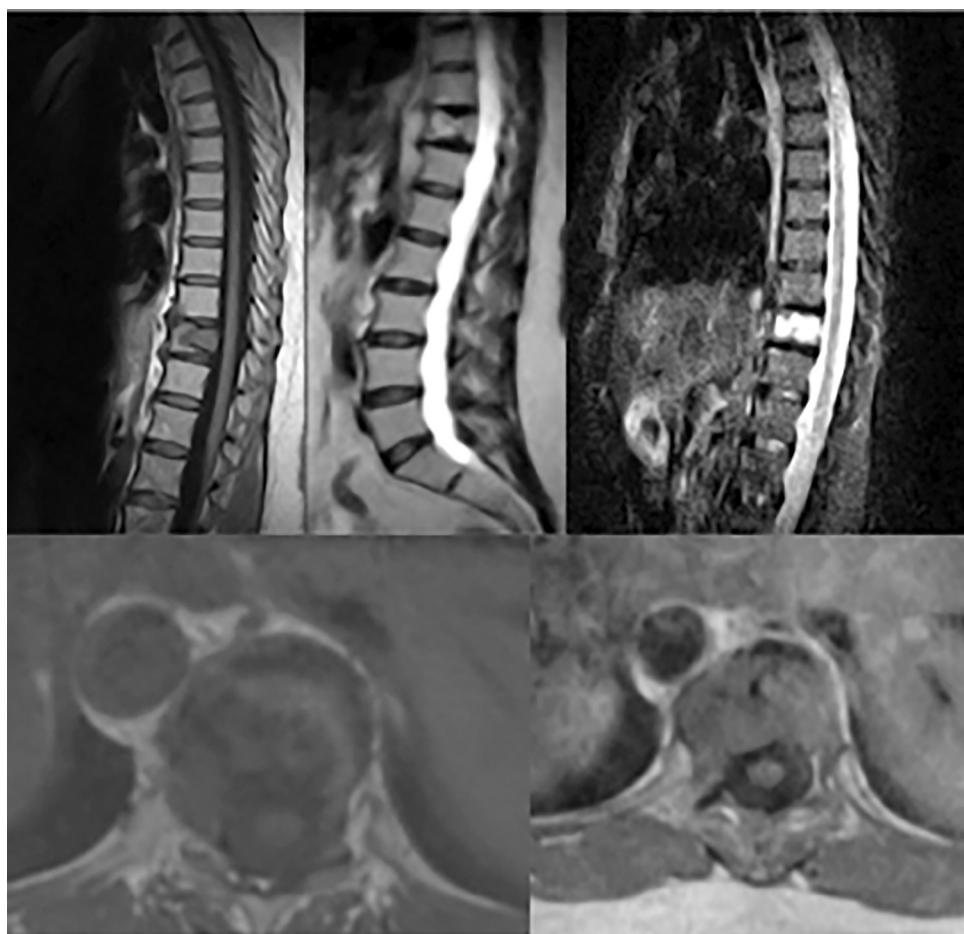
MR showed a solitary lesion in T11 while diffuse hypointense on T1-weighted and heterogeneously hyperintense on T2-weighted were observed. Furthermore, a small mass of pre-vertebral soft tissue and anterior epidural and contrast enhancement were detected.
